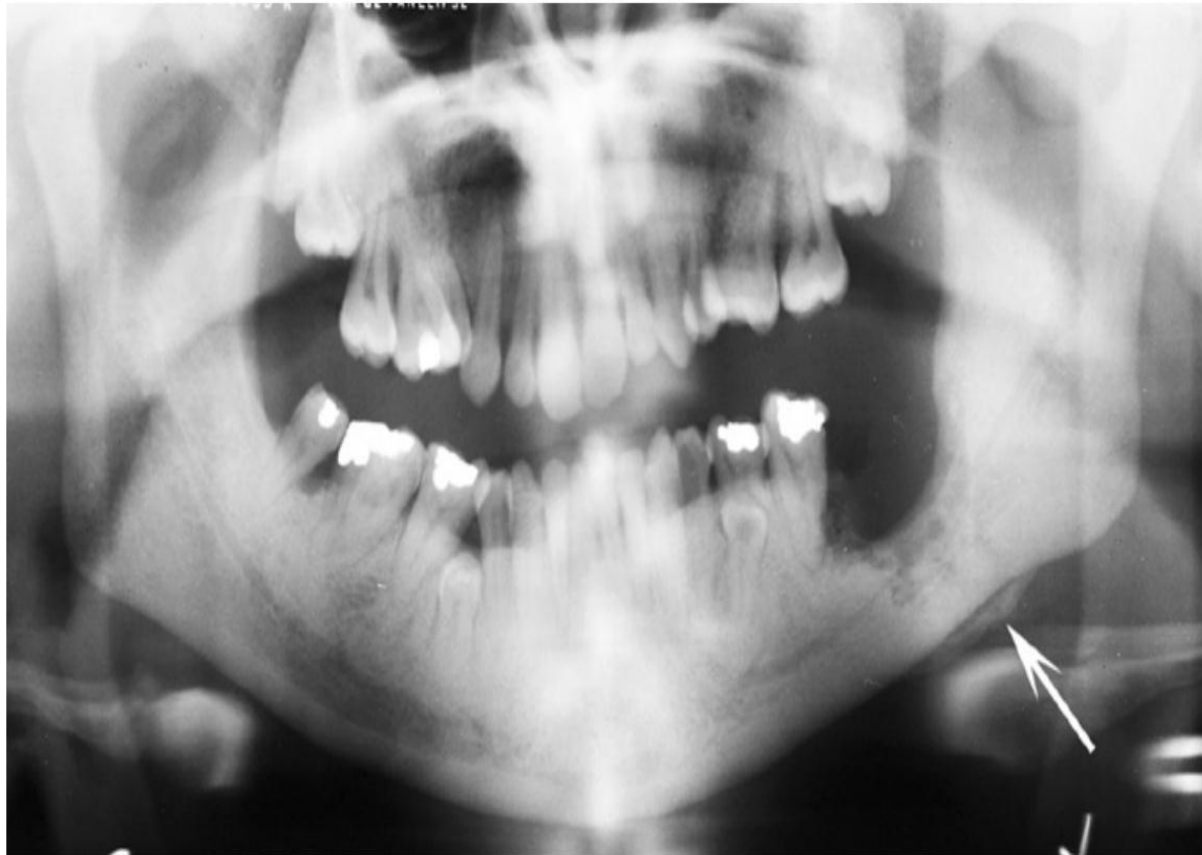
A significant and generalized increase in the radiopacity of the bones is seen on this panoramic radiograph of a patient with osteopetrosis. The inferior alveolar canals are prominently seen and narrowed. Also, there is osteomyelitis in the body of the left mandible with periosteal new bone formation (*arrow*).
